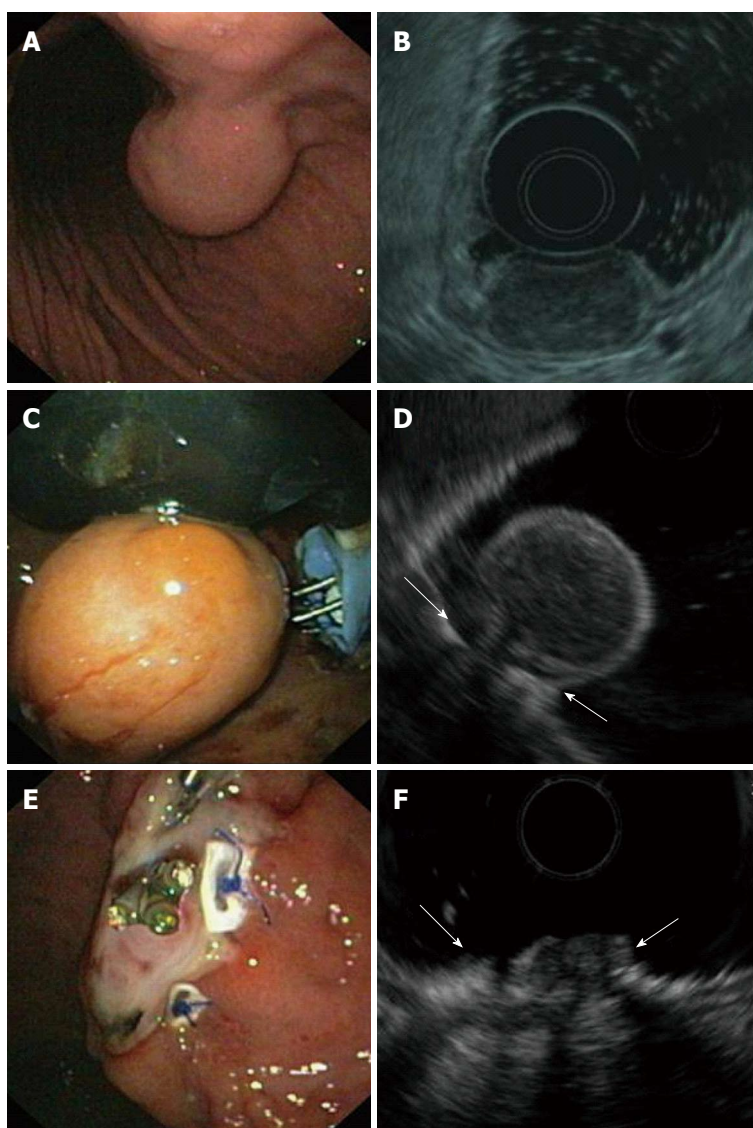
Endoscopic full-thickness resection of a gastric gastrointestinal stromal tumors after prior transmural suturing. A: Endoscopic image of the subepithelial tumor in the gastric corpus; B: EUS-image showing an inhomogeneous tumor arising from the muscularis propria; C: Two transmural sutures are deployed underneath the tumor using the Plicator™ suturing device; D: EUS image after suturing. The PTFE pledges are indicated with arrows; E: Resection site. The transmural sutures are securing gastric wall patency; F: EUS image of the resection site. The PTFE pledges are indicated with arrows. EUS: Endoscopic ultrasonography.
